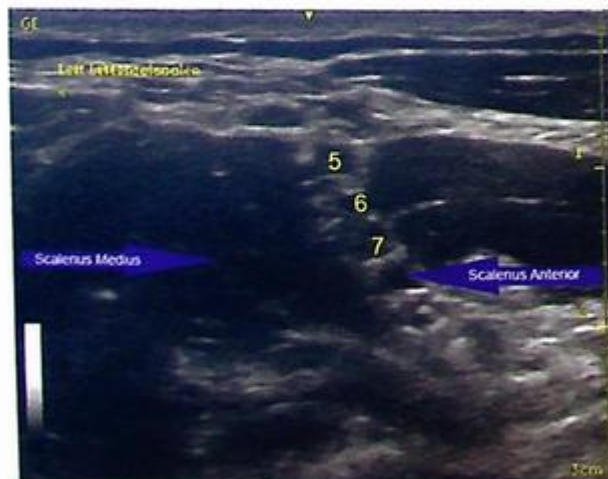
Ultrasound of the interscalene. Note that the roots of the brachial plexus are sandwiched between the scalenus anterior and the scalenus medius.
